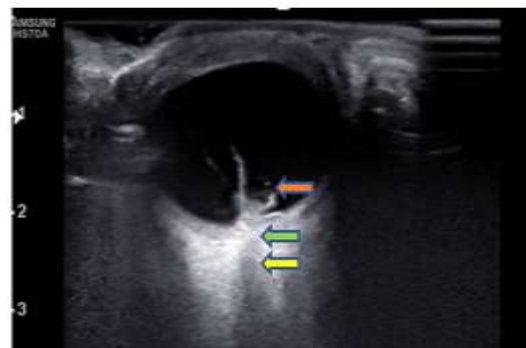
B-scan ultrasound showing vitreous hemorrhage (red arrow), obscuration of optic nerve head (green arrow) and altered echogenicity posterior to optic nerve- globe junction (yellow arrow).
